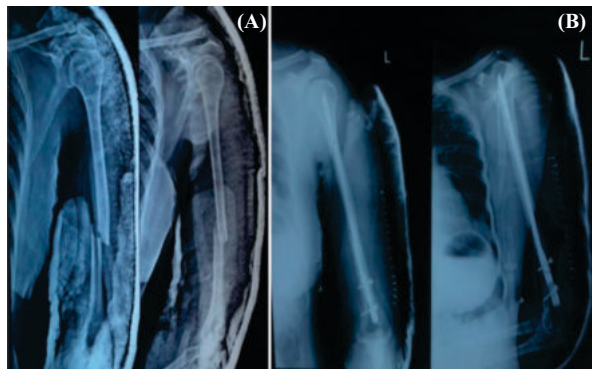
A case of Retrograde Nailing (A) Pre op X-ray (B) Post op X-ray (C) Follow up X-ray
